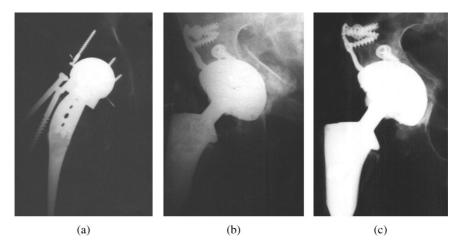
Use of bioactive glass particulate in revision arthroplasty. (a) Preoperative radiograph of failed hip arthroplasty. (b) Immediate postoperative view, with visible graft area visible behind acetabular component. (c) At six months, bone remodelling behind acetabular component is observed.
